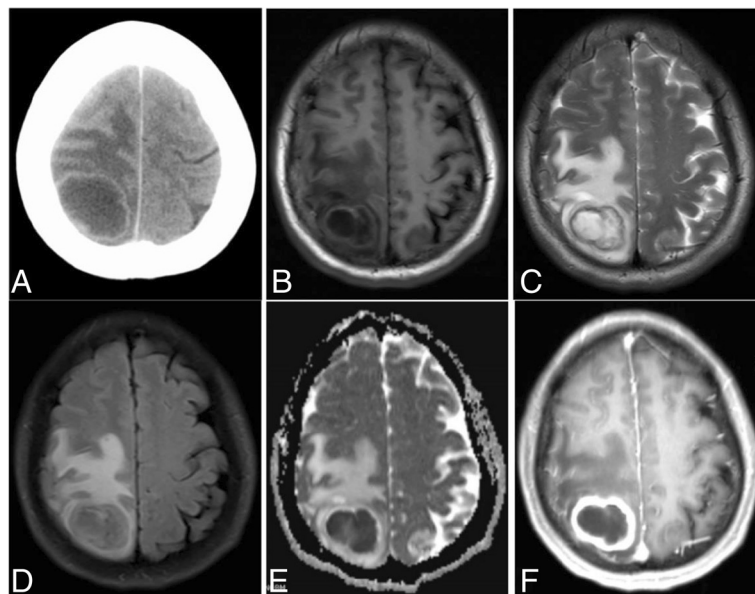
Preoperative brain CT and MRI images
